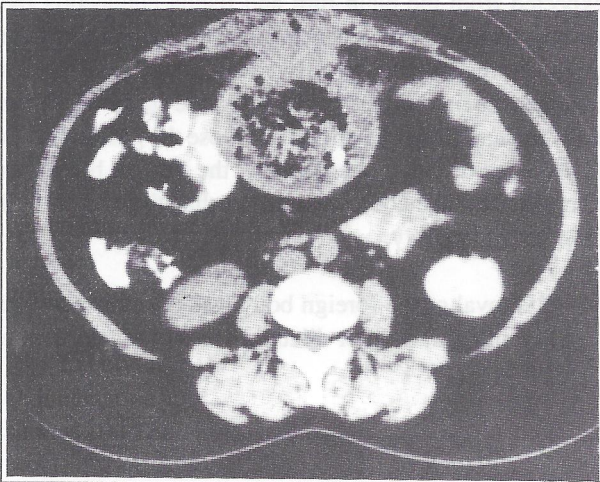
Axial CT mid abdomen: Abscess with thick wall inflammatory soft tissue reaction close to anterior abdominal and transverse colon.
